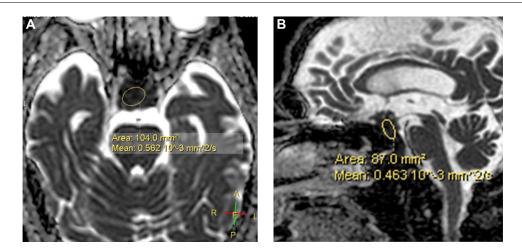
(A, B) DWI sequence, axial plane (A) shows signs of restriction of the pituitary lesion with low values in the ADC map ($0.5 \times 10^{-3} \text{ mm}^2$ /sec). DWI sequence, sagittal plane (B) shows signs of restriction of the pituitary lesion with low values in the ADC map ($0.5 \times 10^{-3} \text{ mm}^2$ /sec).
